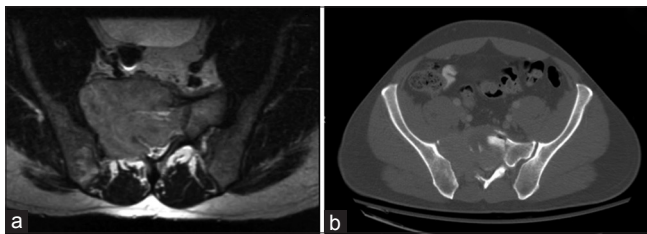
A 42-year-old male with metastatic plasma cell neoplasm. (a) MRI of a lytic sacral lesion with encroachment on neural elements. (b) CT shows involvement of the entire right sacral ala and most of the SI body with a pathologic fracture
